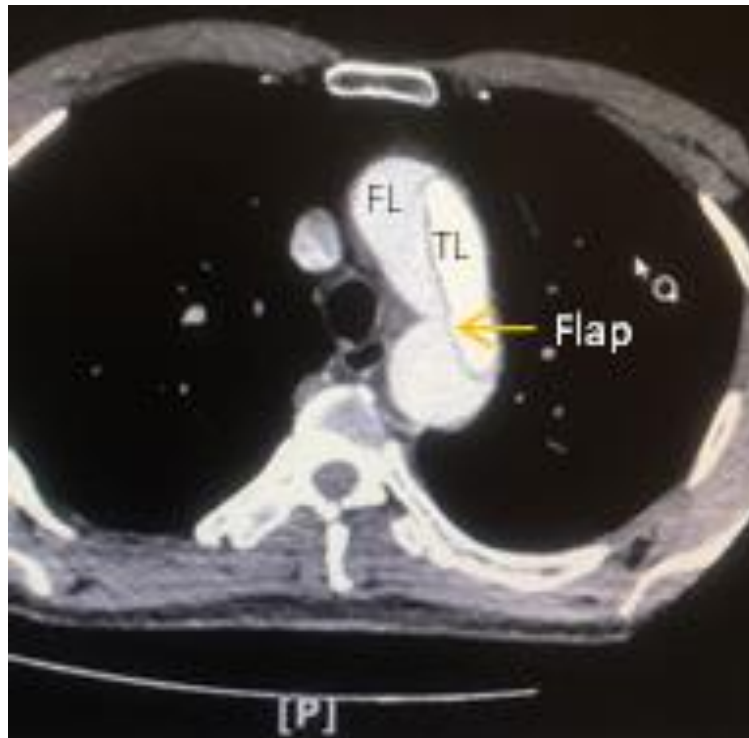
Chest computed tomography with contrast injection shows the dissection flap.
